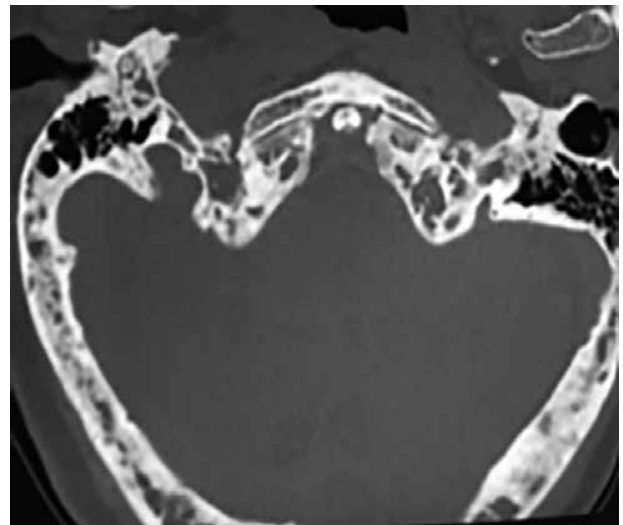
Thickened skull vault with osteolytic and osteoblastic lesions on CT scan.
